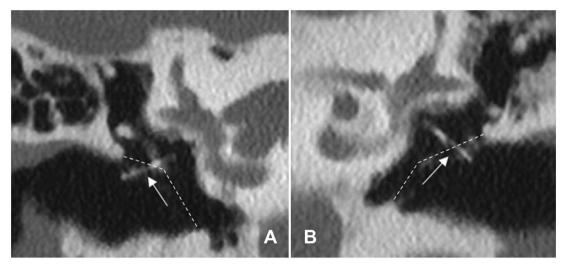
HRCT scan, coronal view Case 1 (A) and Case 4 (B) showing right and left middle ear respectively with luxated piston indicated by white arrows. A: loop is positioned lateral from TM; disconnection from the stapes foot plate. B: loop protruding through the TM, and absence of connection with the stapes foot plate.
